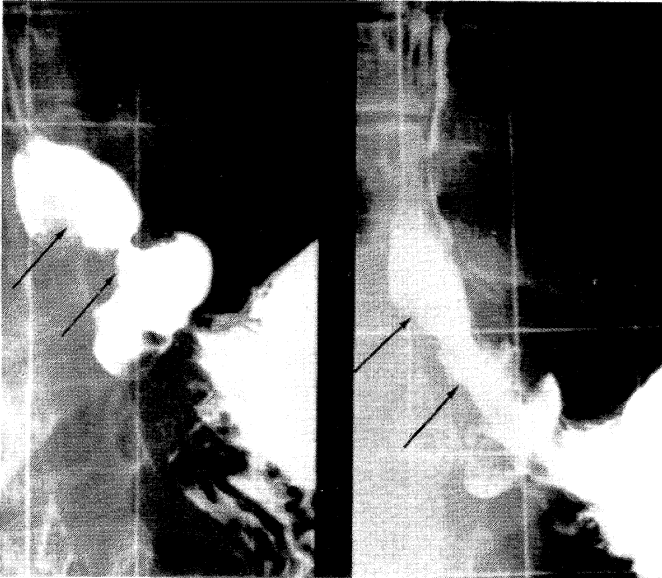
Barium swallow showing adenocarcinoma of gastroesophageal junction before (left) and after (right) laser therapy. Radiographs are taken against a 2 cm grid to quantitate the size of the lumen
